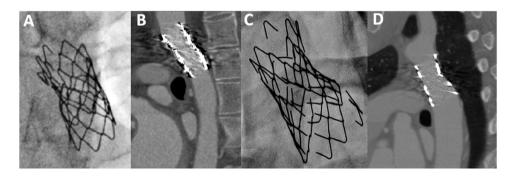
Two examples of stent fractures and aortic wall integrity. A and C, stent fractures; B and D, CT performed at the time of fluoroscopy. CT, computed tomography.
